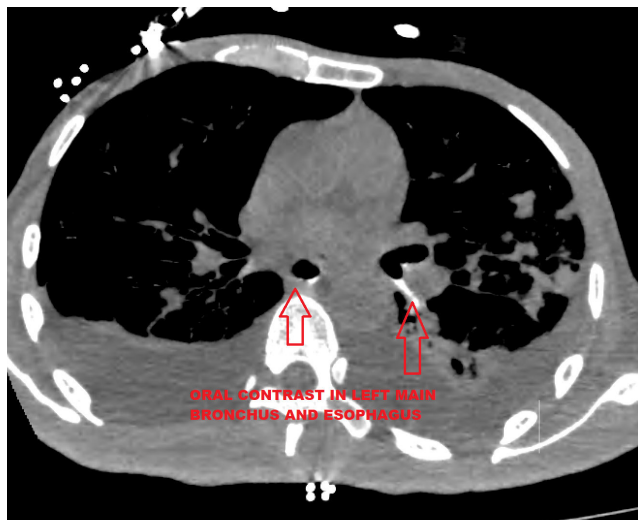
Oral contrast CT study showing contrast in left main bronchus and oesophagus
